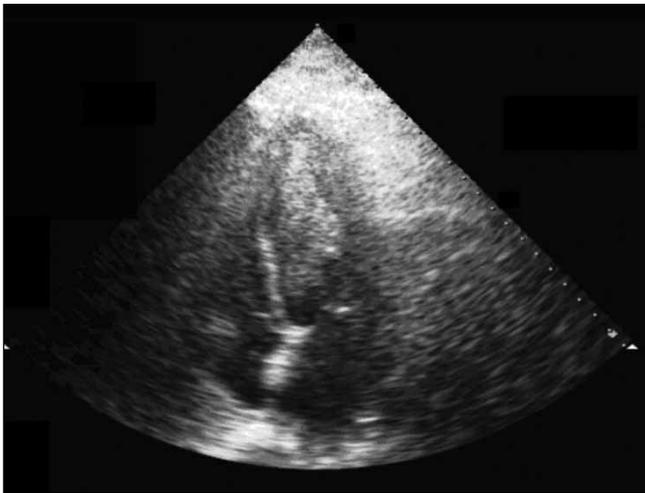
Transthoracic echocardiogram shows a large mobile thrombus occupying 60% of the left ventricular cavity.
